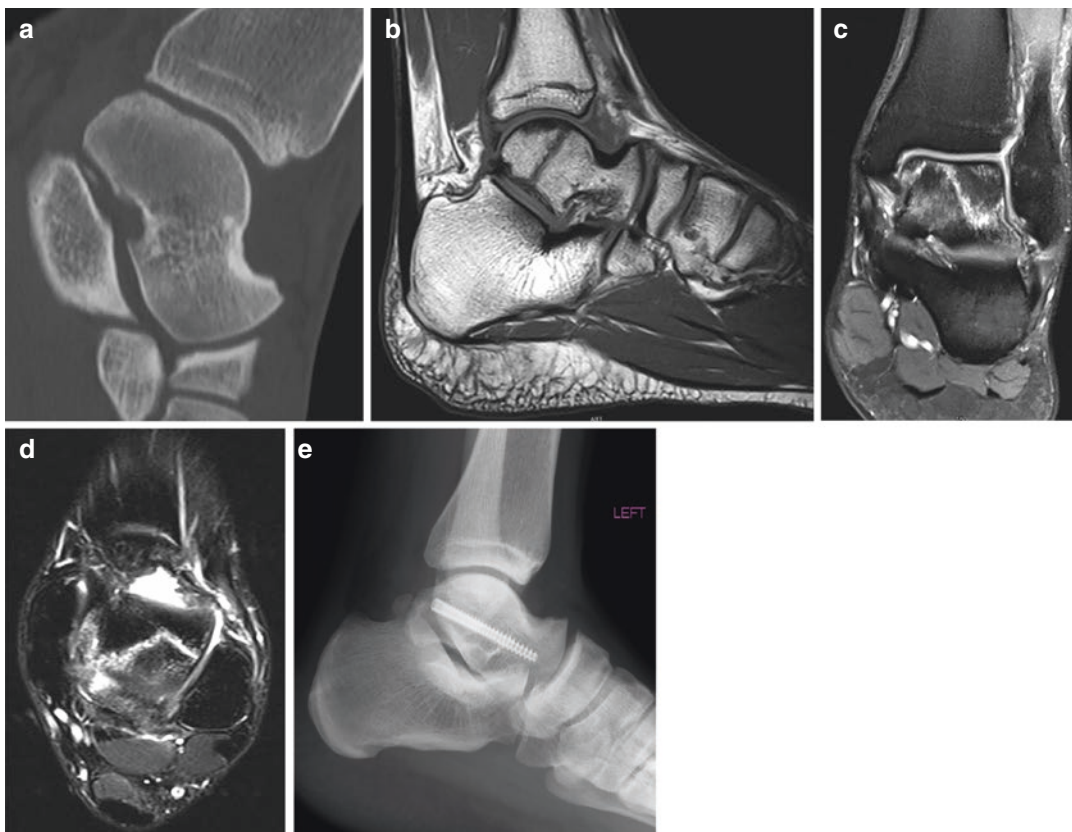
(a) Sagittal CT image of a professional football player with sudden ankle pain after a preseason training camp. (b) Sagittal T1 MRI image of a talar body stress fracture. Note the Hawkins sign. (c) Coronal T2 MRI image of the progressive diastasis of the talar body stress
